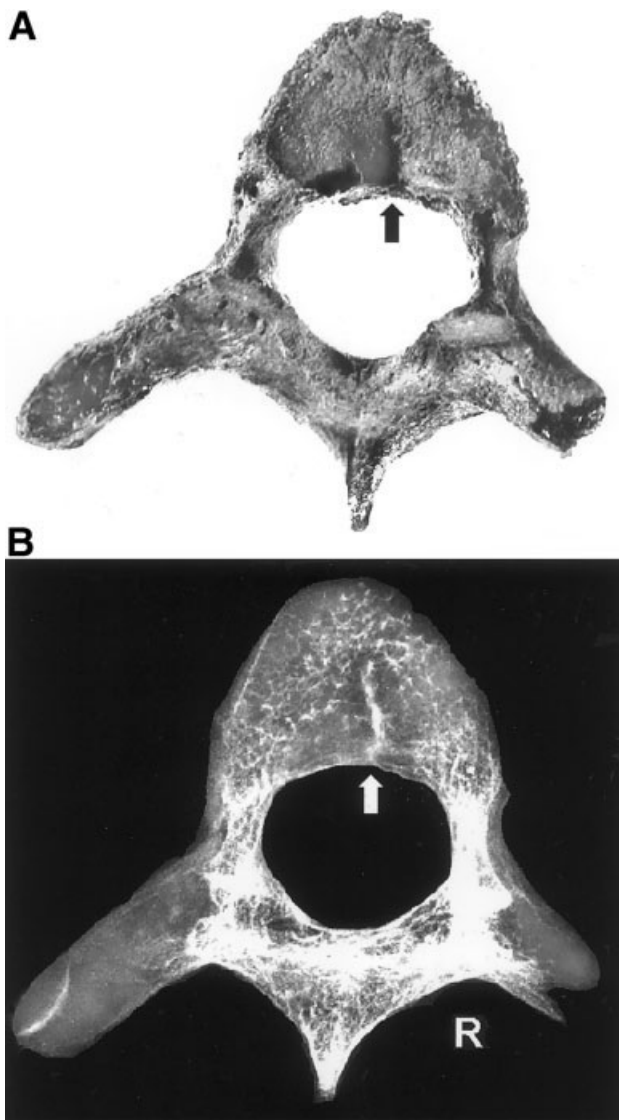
Fourth thoracic vertebra, with a linear defect (arrow) to right of midsagittal line that communicates with neural canal. A: Superior view. B: Radiograph (view from above). Middle-aged adult female from Inuksivik. Table 2, case 25.
